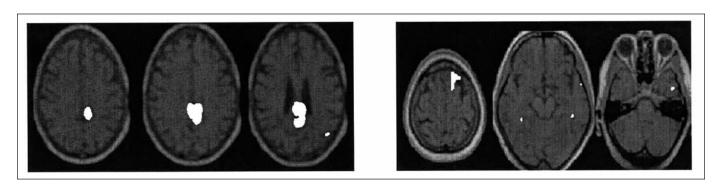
FDG PET showing retrosplenial and precuneus hypomertabolism in AA (left side) and left frontal and inferior temporal and bilateral enthorinal cortex hypometabolism in BB (right side).
